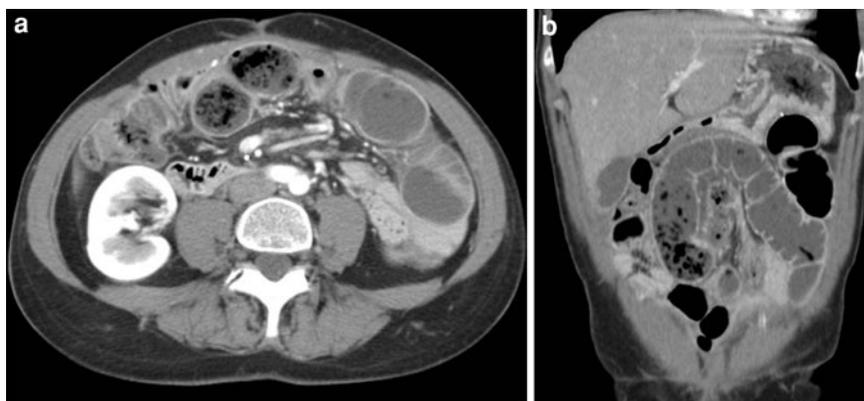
Small-bowel obstruction. Axial CT scan (a) and multiplanar coronal reconstruction (b) show dilated jejunal loops at the level of the mesogastrium and collapsed ileal loops. The small-bowel feces sign is observed near the point of obstruction
